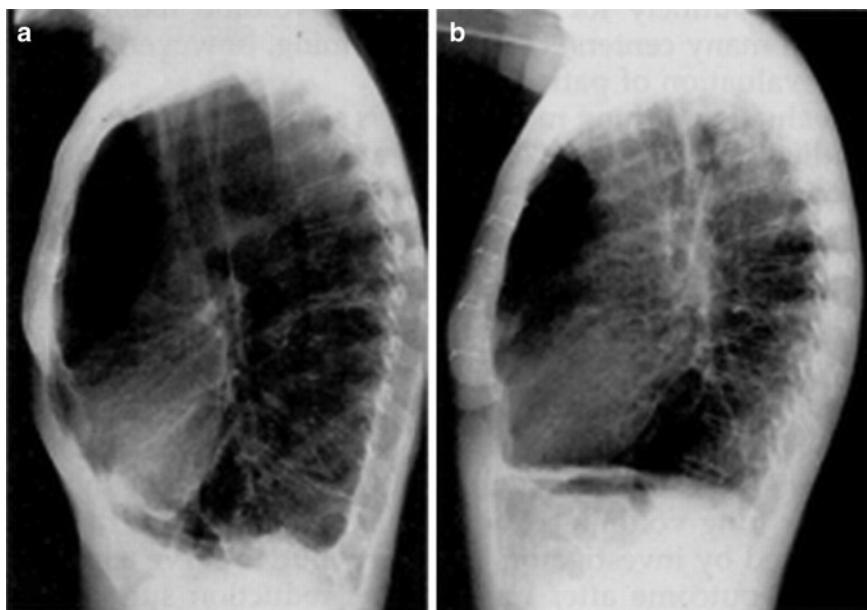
(a) Depicts a high-resolution computed tomography (HR-CT) scan of a patient presenting with inhomogeneous distribution of emphysema. Parenchymal destruction is greater in the ventral portions of the lung; thus, the functional portions are easily distinguished from nonfunctional segments. (b) Depicts a HR-CT of a patient with homogeneous distribution of emphysema. It is much more difficult to determine which segments need to be resected.
